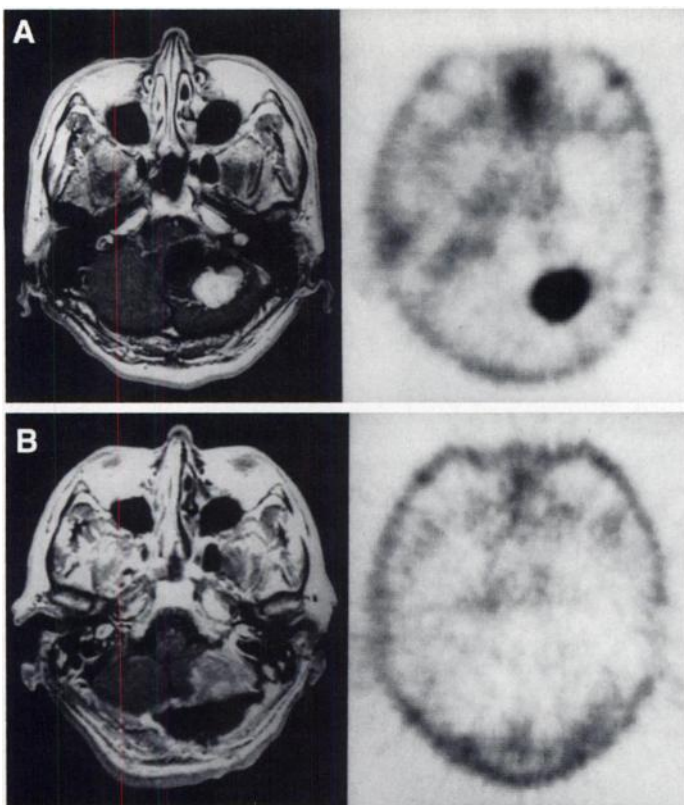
Patient 2 with a brain tumor (hemangioblastoma). (A) MRI with enhancement (left) and PET with $[^{11}\text{C}]$ choline (right). Tumor-to-normal brain $[^{11}\text{C}]$ choline uptake ratio, 27.5; tumor-to-normal brain CBF ratio, 2.0. (B) Same patient after resection of the brain tumor. MRI with enhancement (left) and PET with $[^{11}\text{C}]$ choline (right).
